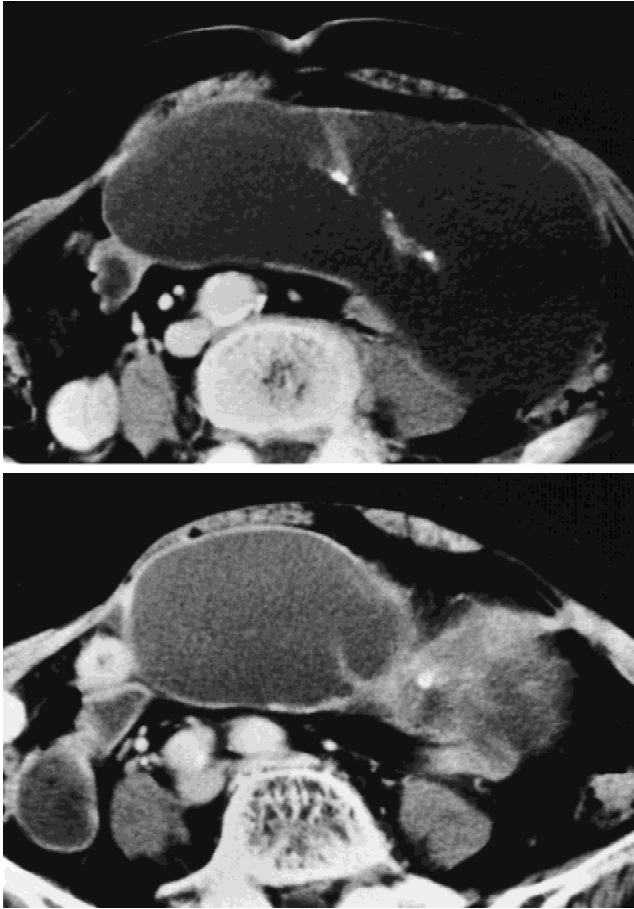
CT. A large, generally low-density tumor shows calcification and septation.
